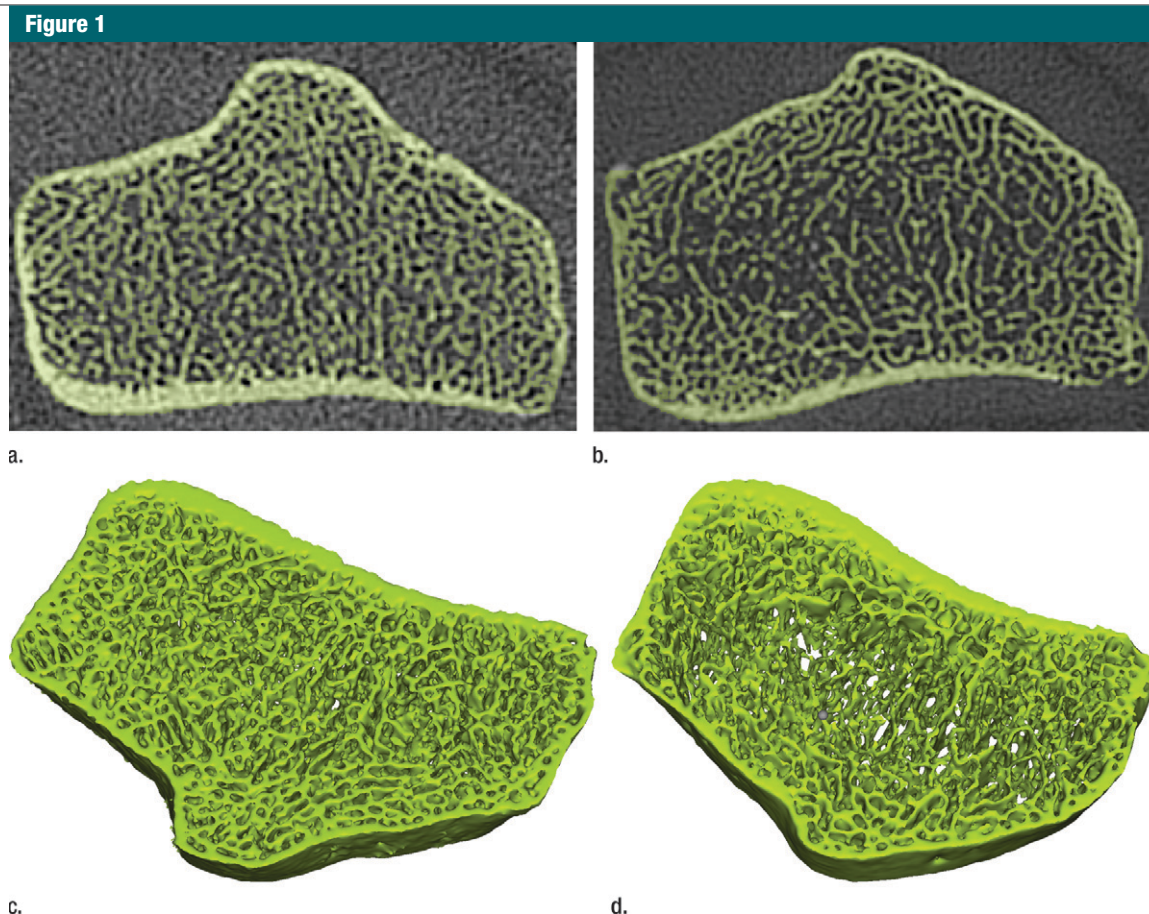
Axial flat-panel volume CT images of distal radius in (a) control subject and (b) woman with AN. Masks (green) created by segmenting out the cortical and trabecular bone structure with a thresholding technique are overlaid on the flat-panel volume CT images. Corresponding three-dimensional models for (c) control subject and (d) woman with AN were created with software (MIMICS) by compiling the masks of 5-mm sectional flat-panel volume CT images. Flat-panel volume CT images and three-dimensional models clearly demonstrate rarefaction of trabeculae and thinning of the cortical shell of the distal radius in AN compared with that in control subject.
